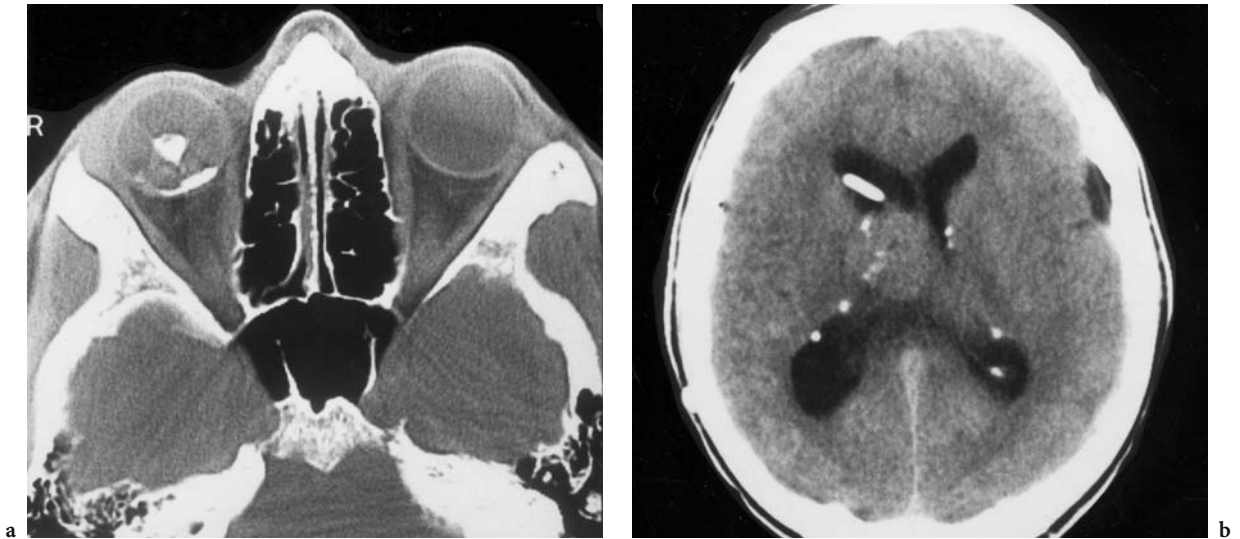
A 21-year-old man with Pringle disease. Diagnosis: phthisis. CT: a Axial view with ocular calcification of the globe and posterior sclera. b Axial cranial view with ependymal calcification and giant cell astrocytoma, extending into the right lateral ventricle (state after ventricular shunting for occlusive hydrocephalus). (With permission of Dr. R. Gustorf-Aeckerle, Katharinen Hospital, Stuttgart)
